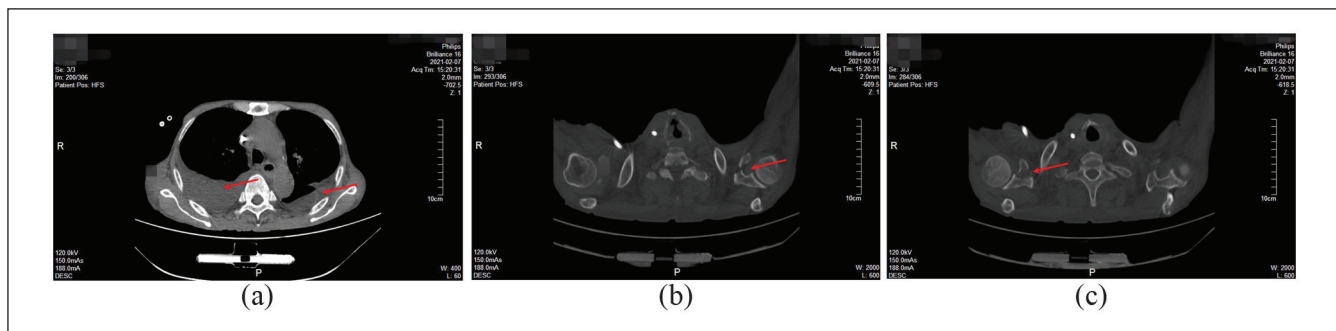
CT scan on 7 February 2021. The bilateral pleural effusion (a, red arrows) and bilateral coracoid process fracture are still present, with no obvious bone destruction at the fracture end (b and c, red arrows).
